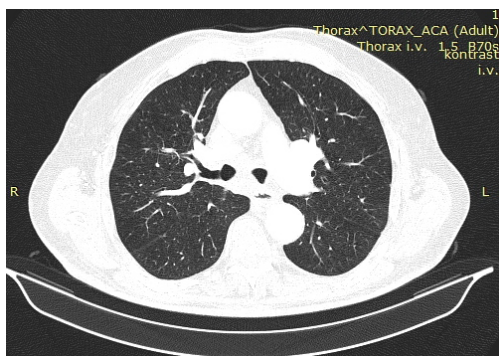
Chest CT in lung window one month after steroid therapy and prior to chemotherapy shows improvement in interstitium.
